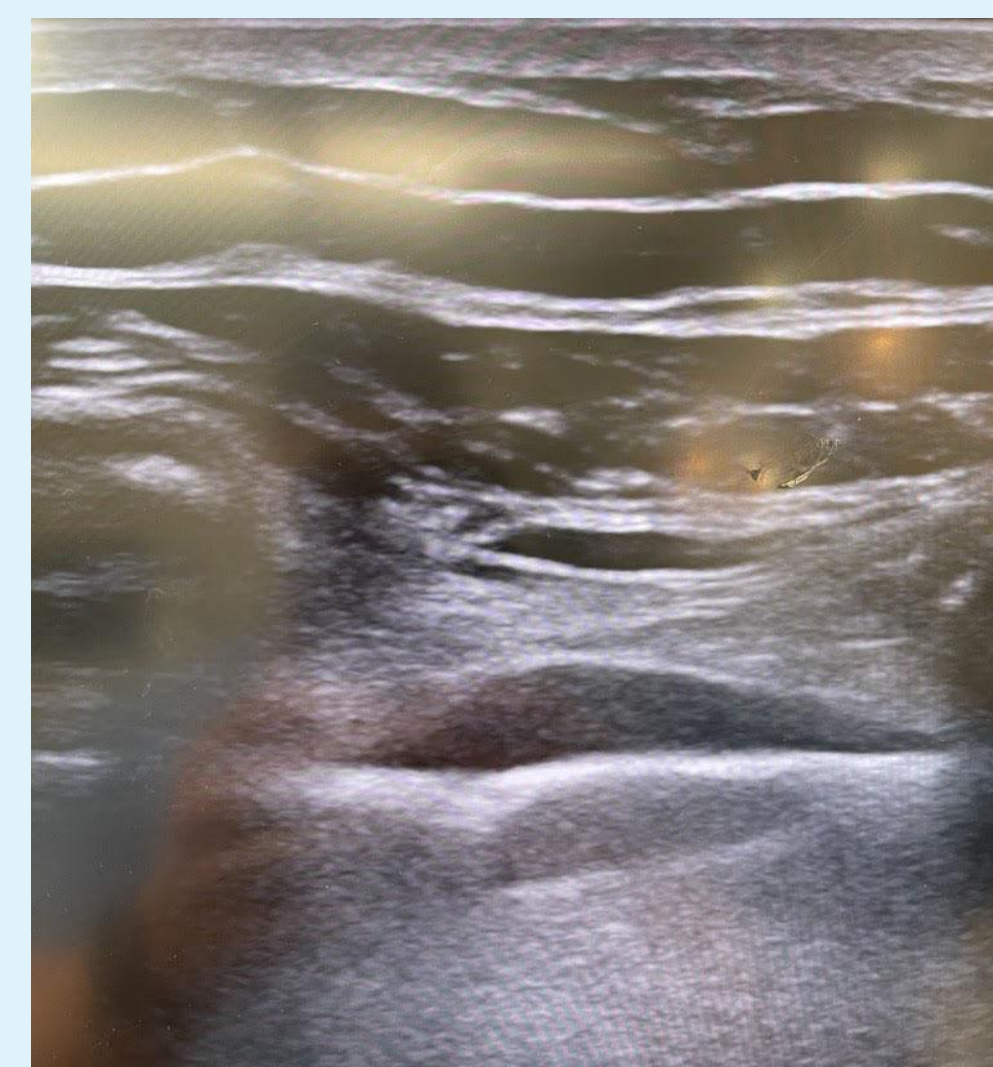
Ultrasound imaging showing anatomy prior to TTP block. Fig 3b. Ultrasound imaging with false color overlay showing the anatomy during the block.
